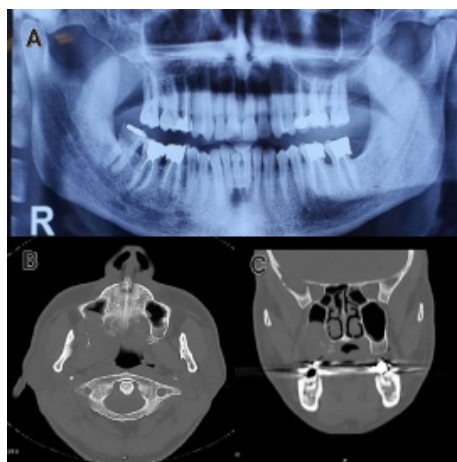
I Radiographs in A) panoramic view demonstrating a radiolucent lesion with poorly defined margins extending from the maxillary left second premolar to the tuberosity, with destruction of the maxillary sinus floor and tuberosity and B) Axial CT-scan and C) Coronal CT-scan revealing a soft tissue mass (4.1 cm × 3.2 cm) eroding the ipsilateral maxillary tuberosity, palatine bones, medial pterygoid plate, and sinus floor, with invasion into the oral cavity, maxillary sinus, oropharynx, and masticatory spaces.
